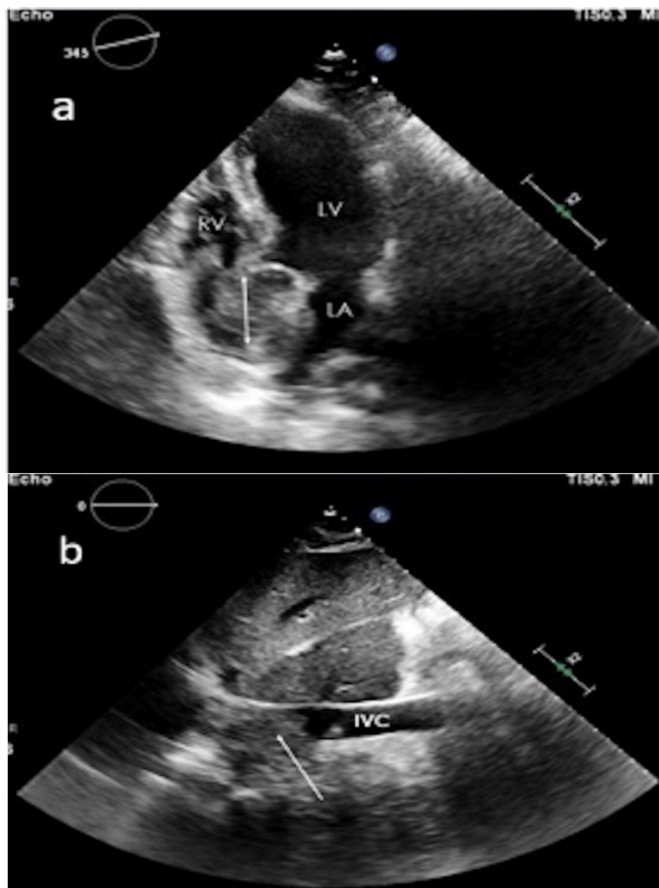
Transthoracic Echocardiogram demonstrating findings: a Thrombus present in the RA (white arrow). b Filling defect in the IVC (white arrow)
